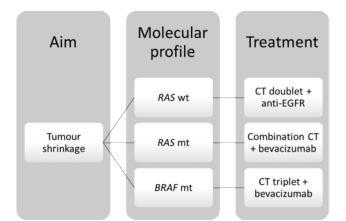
Treatment algorithm for tumours in need of shrinkage and conversion to resectable disease. Wild-type (wt). Mutation (mt). Chemotherapy (CT).
